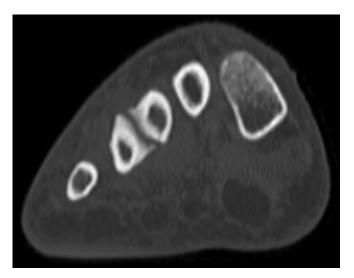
Computed tomography scan of the left foot demonstrating partial osseous coalition.
